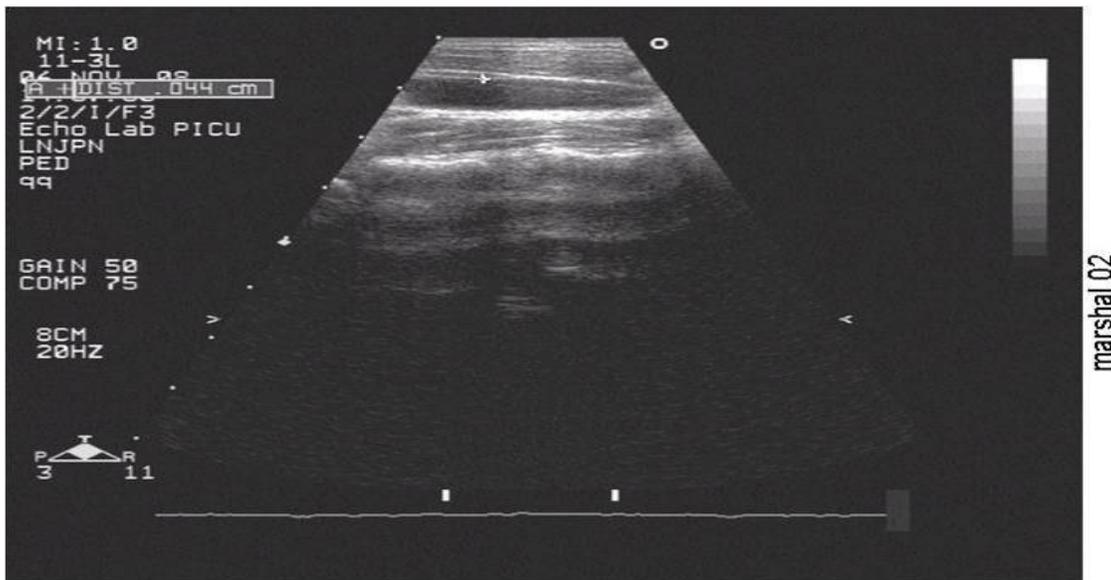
Measurement of carotid intimo-medial thickness on B-mode echocardiography.
